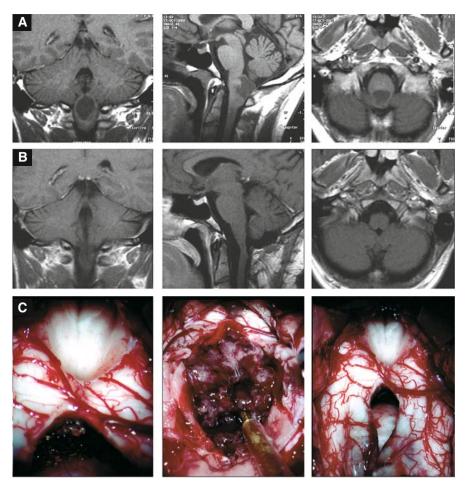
44-year-old undergraduate of engineering presented with increasing dysphagia and dysarthria associated with paresthesia in the lower limbs and left arm with the sensation it was moving upwards. Preoperative MRI (A) show a non-enhanced intra-axial cervicomedullary tumor which was completely removed (B) through a midline suboccipital-C2 opening. Intraoperative mapping and monitoring of the IX and X cranial nerves as well as the motor and somatosensory potential of the four limbs suggested entering below the calamus scriptorius maintaining the longitudinal myelotomy below the obex (C). The tumor was exposed, debulked with an ultrasonic aspirator and then easily removed. The postoperative course was uneventful and the patient left the hospital with an added modest motor deficit in the extremities of the left hand. At the first follow-up – meantime the patient graduated – he was neurologically intact
